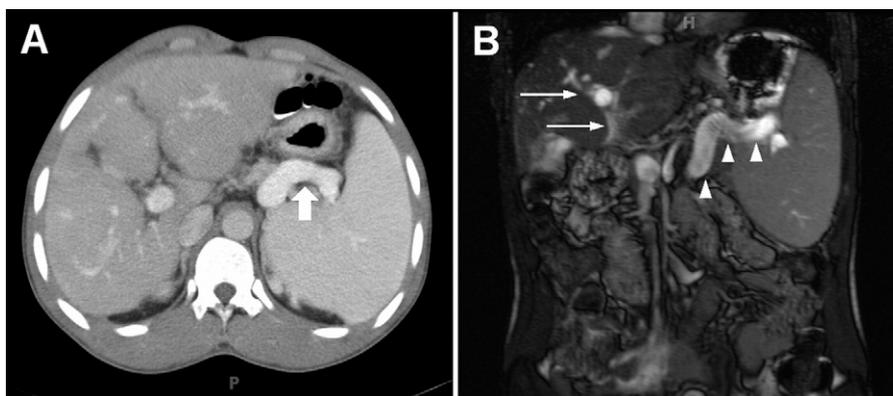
Figure Computed tomography with contrast of the abdomen (Panel A, transverse image) revealed splenomegaly, and splenic vein enlargement as evidence of portal hypertension. Magnetic resonance imaging with gadolinium (Panel B, coronal image) revealed splenomegaly, enlarged splenic and superior mesenteric veins, and periportal edema.
